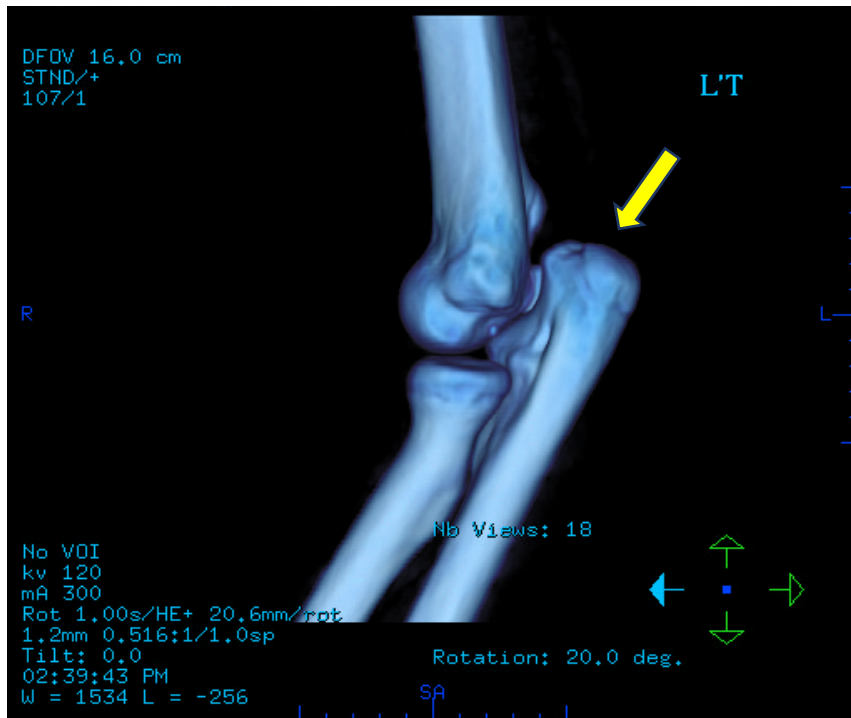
December 4, 2007 left elbow CT: left elbow with habitual dislocation
